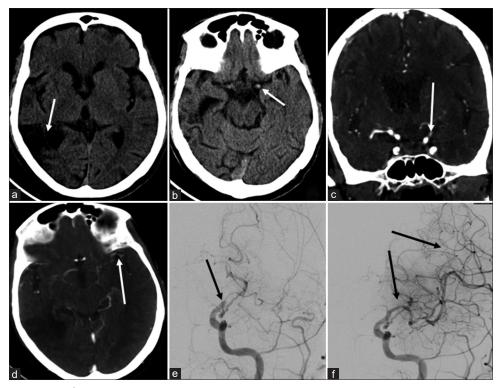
Case 2. Non-enhanced CT shows a chronic infarct involving the right inferior parietal and right posterior temporal lobe (white arrow, a). Hyperdense focus is noted in the left Sylvian fissure (White arrow, b) corresponding to the "hyperdense MCA sign". Terminal ICA occlusion is noted on the left side on CT angiogram (White arrow, c) with good collaterals (White arrow, d). On pre-thrombectomy digital subtraction angiogram (e), occlusion of the left terminal ICA is evident (Black arrow, e). Post-thrombectomy angiogram (f) shows complete recanalization of the left MCA territory (Black arrows, f)
